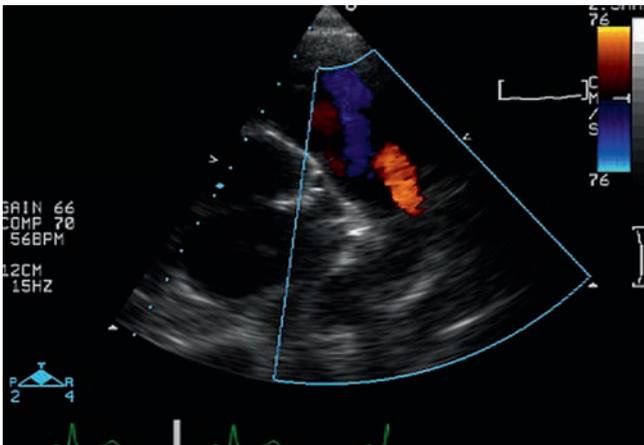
Patent ductus arteriosus. Colour flow Doppler demonstrating aortic to pulmonary flow in the short-axis view. The red colour represents the diastolic flow through the arterial duct
